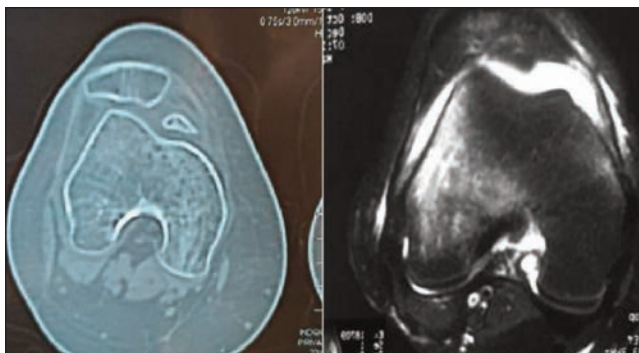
CT scan and MRI showing osteochondral displaced fracture of patella.
